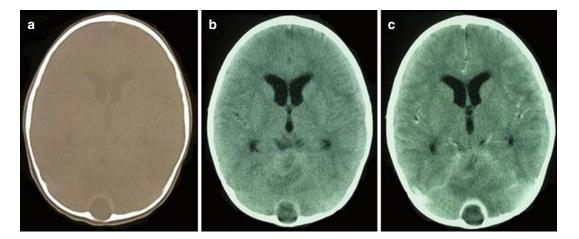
CT images of an occipital dermoid. (a) Bone window study demonstrates scalloping of the occipital bone, (b) non-contrast CT, (c) contrast enhancement of the cyst wall due to inflammation
